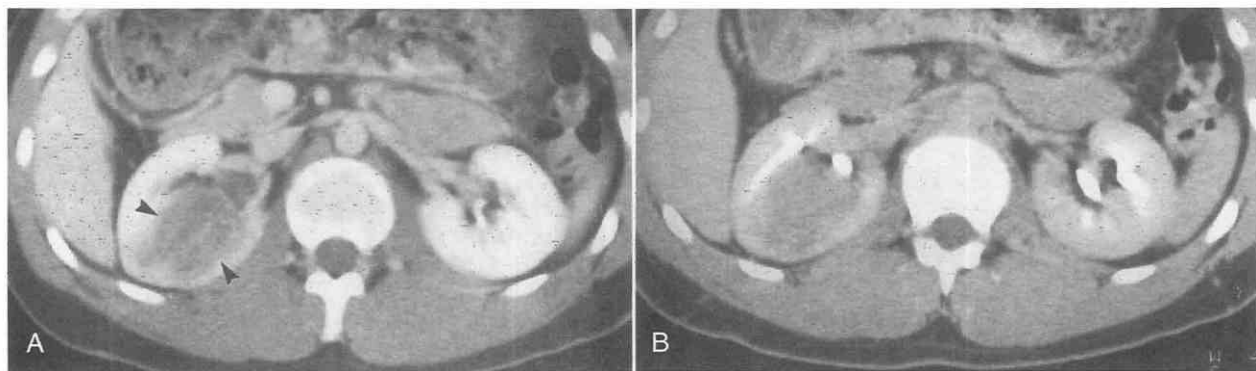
Transitional cell carcinoma of the right renal pelvis in a 20-year-old man associated with cyclophosphamide therapy administered 6 years earlier. *A*, Dynamic CT scan obtained immediately after bolus injection of contrast material shows an enhancing mass (arrowheads; attenuation value = 71 HU) in the right renal pelvis. The precontrast attenuation value was 43 HU. The mass obliterates and invades the renal sinus fat. A poorly defined margin between the tumor and the renal parenchyma indicates parenchymal invasion. *B*, A CT scan obtained 5 minutes after *A* shows displacement of the opacified collecting system. (From Levine E: Transitional cell carcinoma of the renal pelvis associated with cyclophosphamide therapy. *AJR Am J Roentgenol* 159:1027-1028, 1992.)
